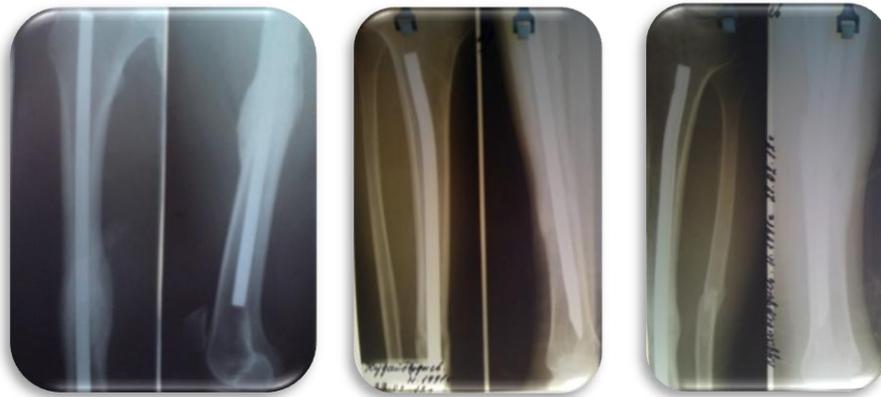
X-ray 11 months after surgery: complete consolidation of the right and both tibia
